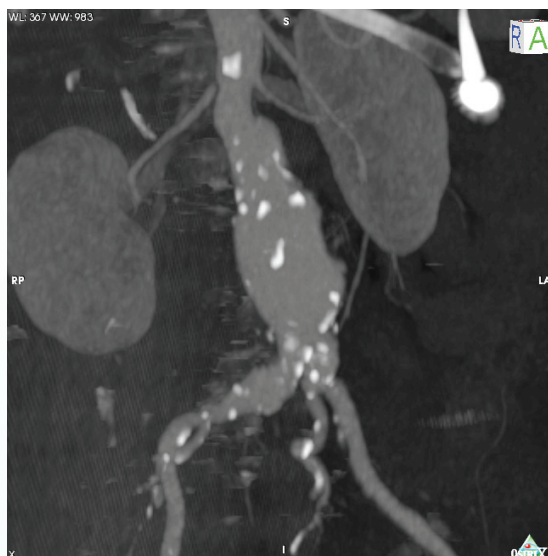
3D RECONSTRUCTION OF CT AORTOGRAM SHOWING AAA
